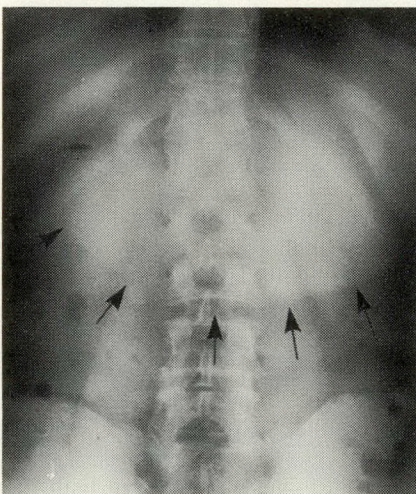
Plain film shows stomach distended with fluid.
